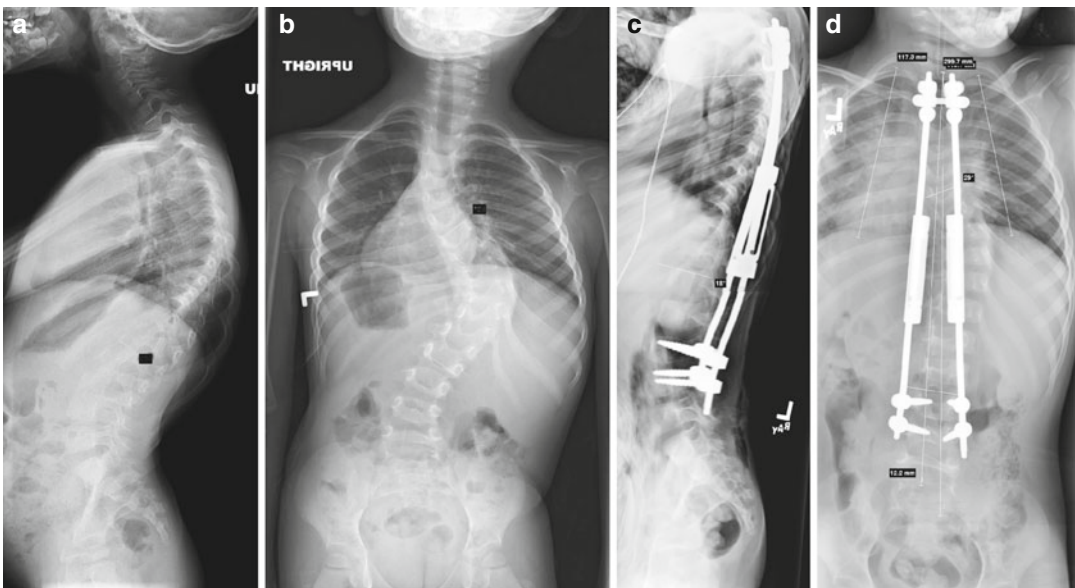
(a, b) Severe progressive scoliosis in a 4-year-old patient with idiopathic infantile. (c, d) Post-initial surgery radiographs
